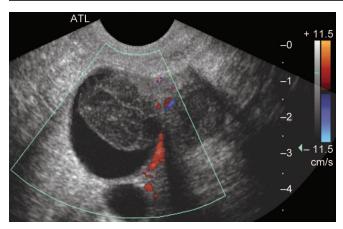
Transvaginal ultrasound of the adnexa. Note cystic structure with a well-defined wall, internal reticular and linear echoes and no internal flow on color Doppler. Findings are consistent with hemorrhagic cyst
